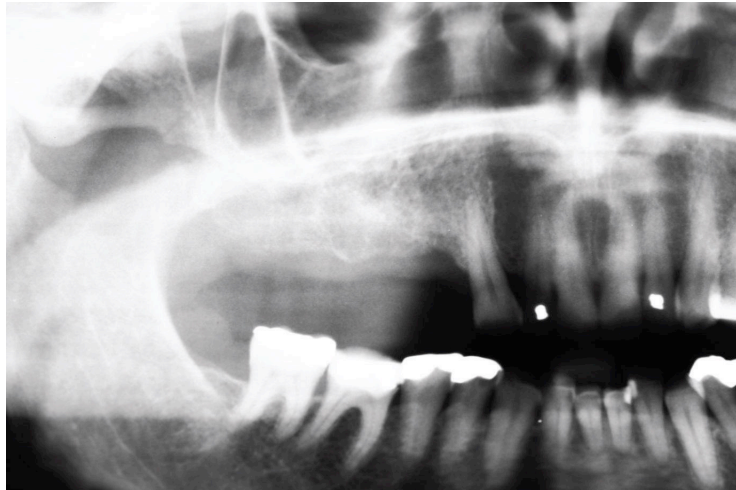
Radiograph showing new bone formation.
